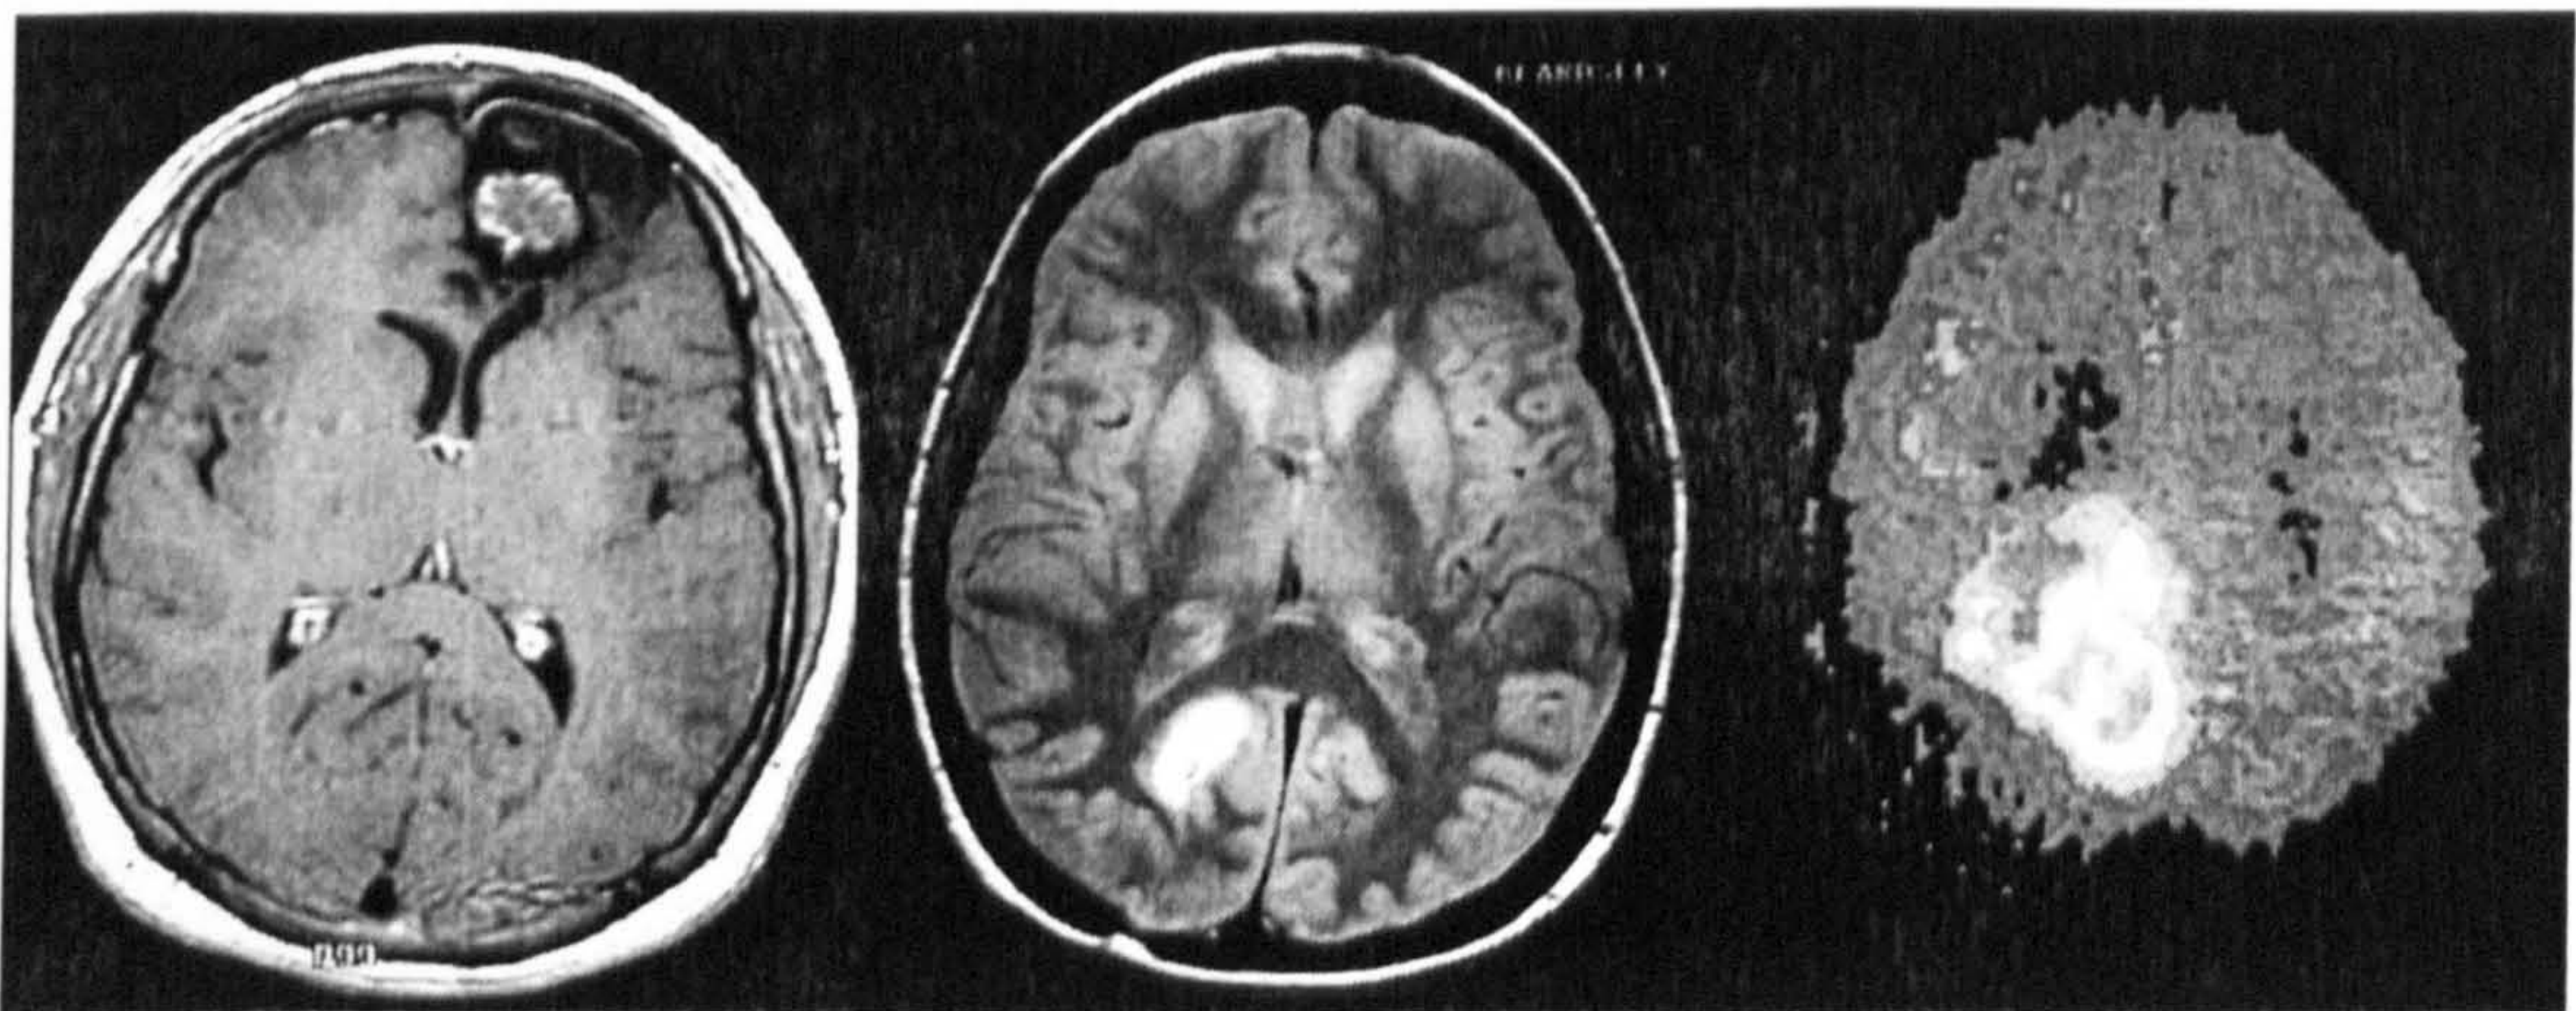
(Left) CT [Alvira 1997], (middle) MRI [Beardsley 2004] and (right) PET [Medica.de 2004] images.
